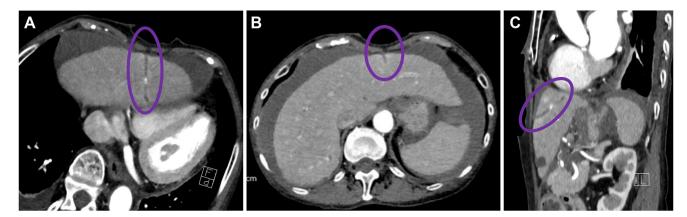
Chest and abdominal computed tomography after removing the drainage tube. A: Axial view (higher slice). The purple circle indicates the hole from penetration of the drainage tube. B: Axial view (lower slice). C: Sagittal view.
